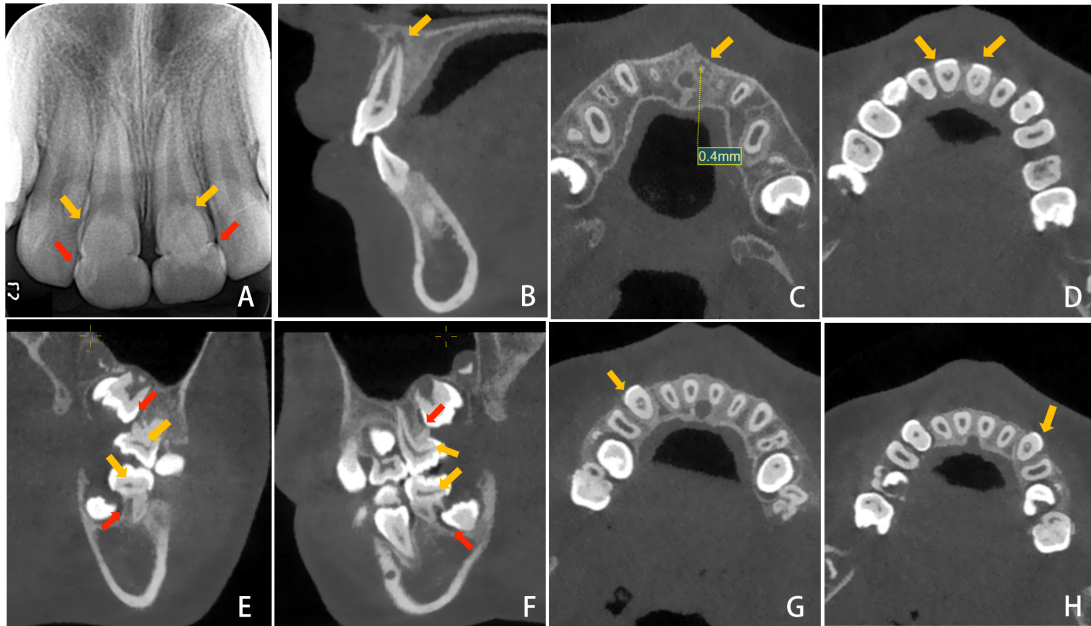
Initial radiographs. (A) Periapical radiograph. The yellow arrows showing the pulpal calcifications, and the red arrows showing the wedge-shaped radiolucent defects at the cervical areas of teeth 11 and 21. (B) Periapical radiolucency (the yellow arrow) associated with tooth 21. (C) The apical foramen of tooth 21 showing an estimated opening diameter of approximately 0.4 mm (the yellow arrow). (D) Calcified masses (the yellow arrows) in the pulp chambers of teeth 11, 21. (E,F) Narrow and linear pulp chambers (the yellow arrows) in teeth 16, 26, 36, and 46; incomplete development of the distal roots (the red arrows) of the first permanent molars; teeth 17, 27, 37, and 47 impacted at the distal cervical root area of the first molars. (G,H) Calcified masses (the yellow arrows) in the pulp chambers of teeth 13, 23.
